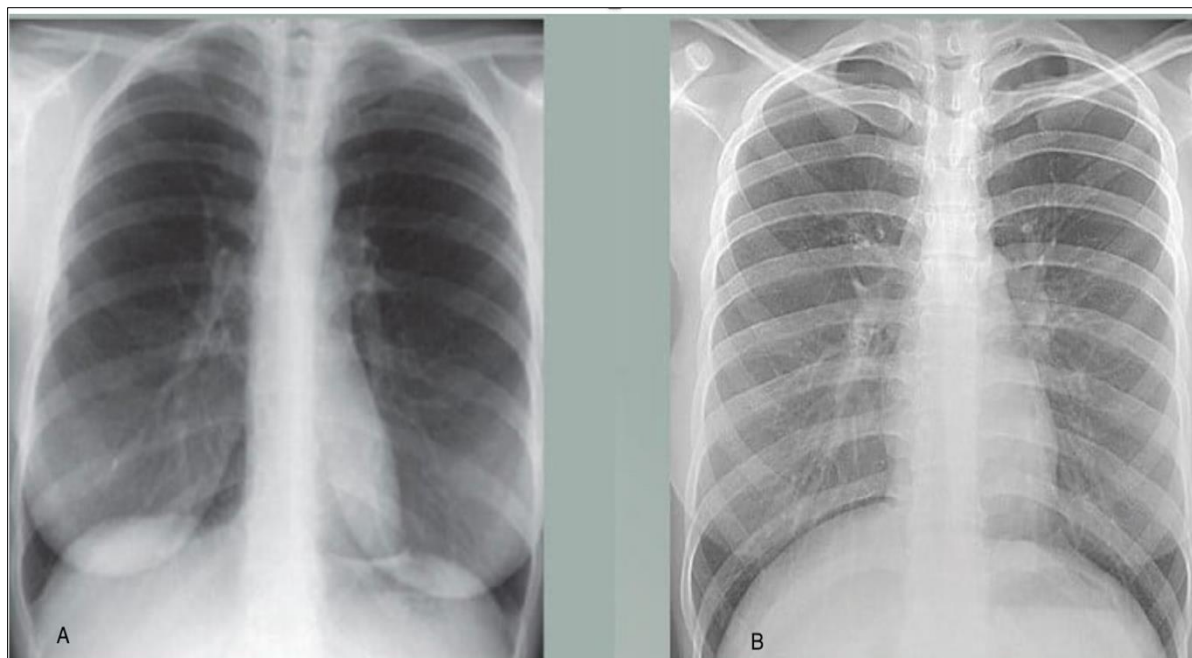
Chest Radiograph taken from Computed x-ray (A) and digital Xray
